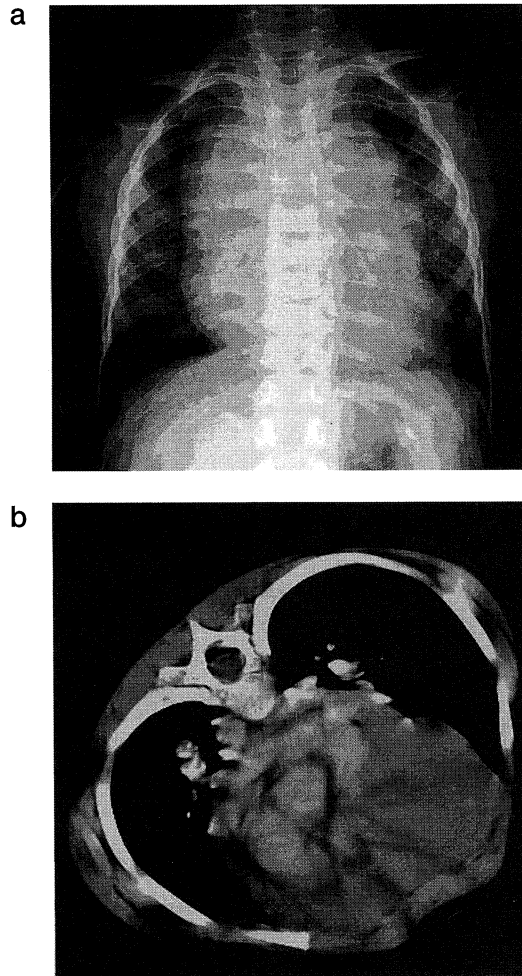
Chest radiograph (a) reveals the widened mediastinum. Computed tomography scan (b) demonstrates a homogeneous anterior mediastinal mass.
